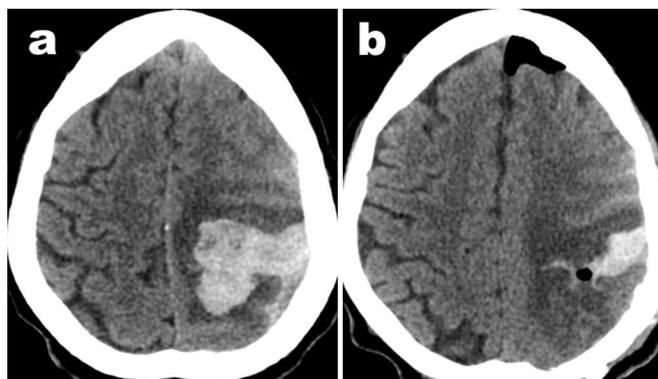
Axial CT images before (a) and the day after (b) the surgical evacuation of a haematoma in the left frontoparietal area.
